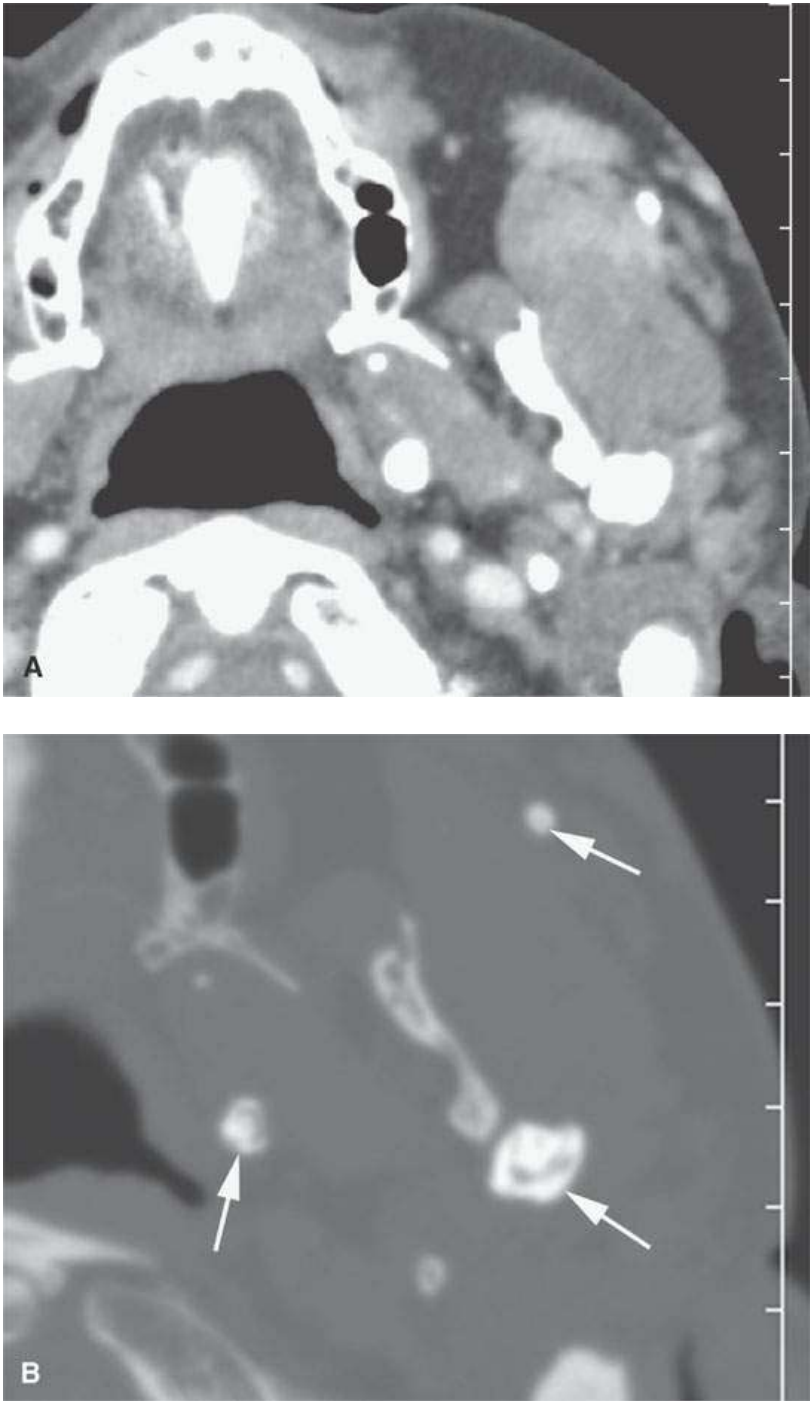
Contrast-enhanced computed tomography of the phleboliths securing the diagnosis of a venolymphatic malformation—a strength of computed tomography in a lesion usually better evaluated with magnetic resonance imaging.
